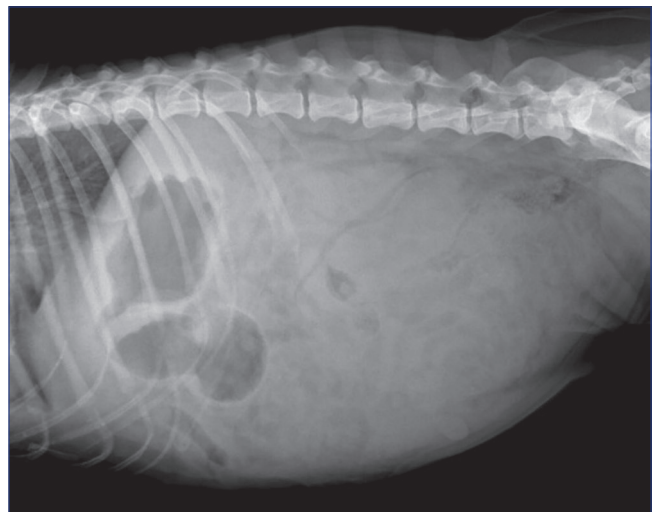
Radiography of the abdomen: Loss of details because of liquid accumulation
